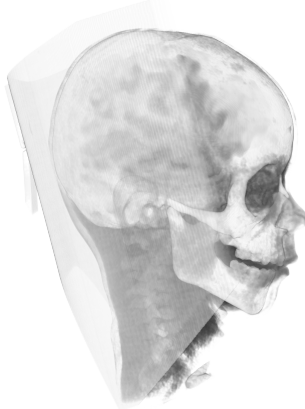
Raw CT-scan data viewed in Simpleware.
